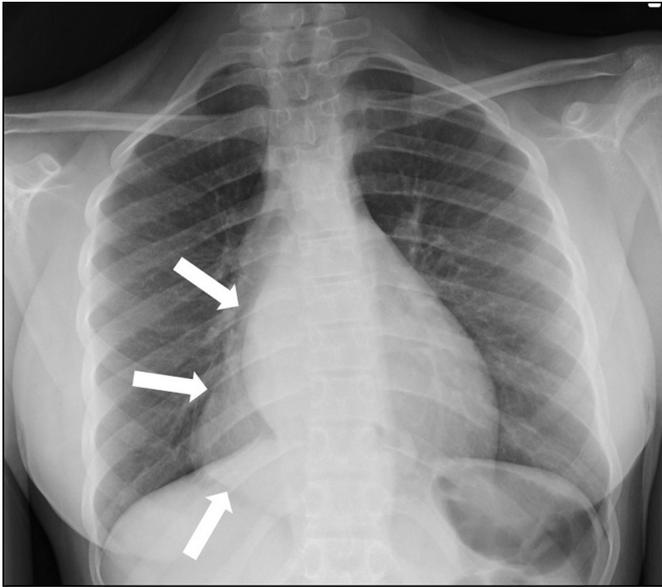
Erect PA radiograph of the chest. The frontal view shows an opacity adjacent to the right heart border and medial hemidiaphragm, neither of which are obscured (arrow).
